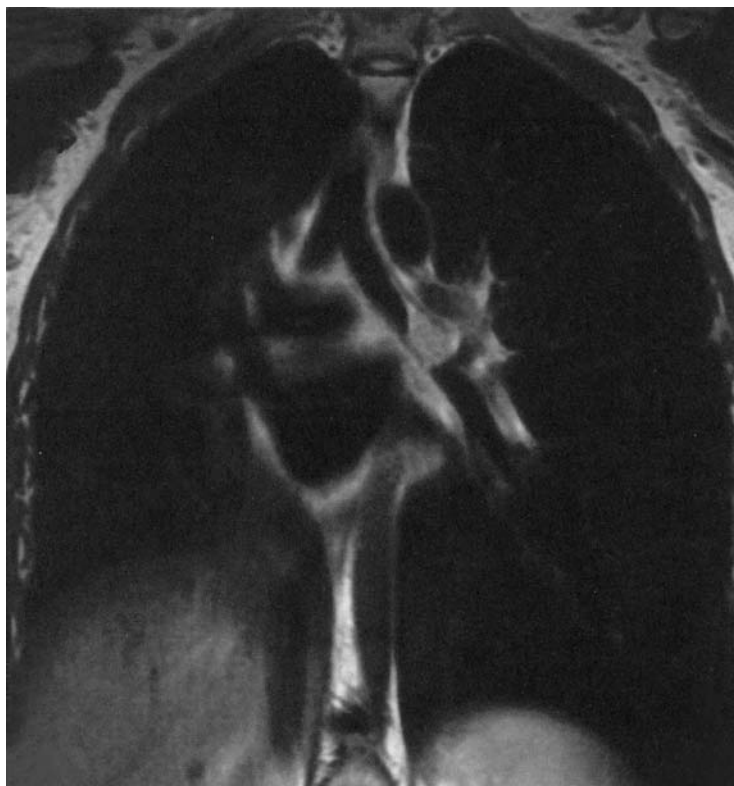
A magnetic resonance image of the chest showing an endobronchial mass in the left main stem bronchus.
